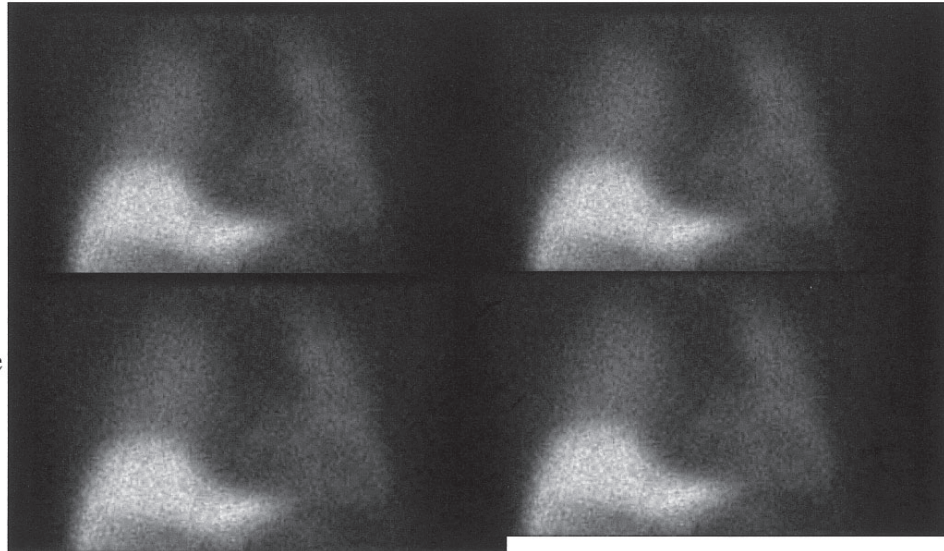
MIBG myocardial scintigraphy on Day 20 and Day 72.
